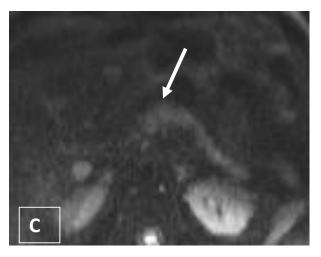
Patient 4. Contrast enhanced CT, MR T2 and MR Dw sequences.
